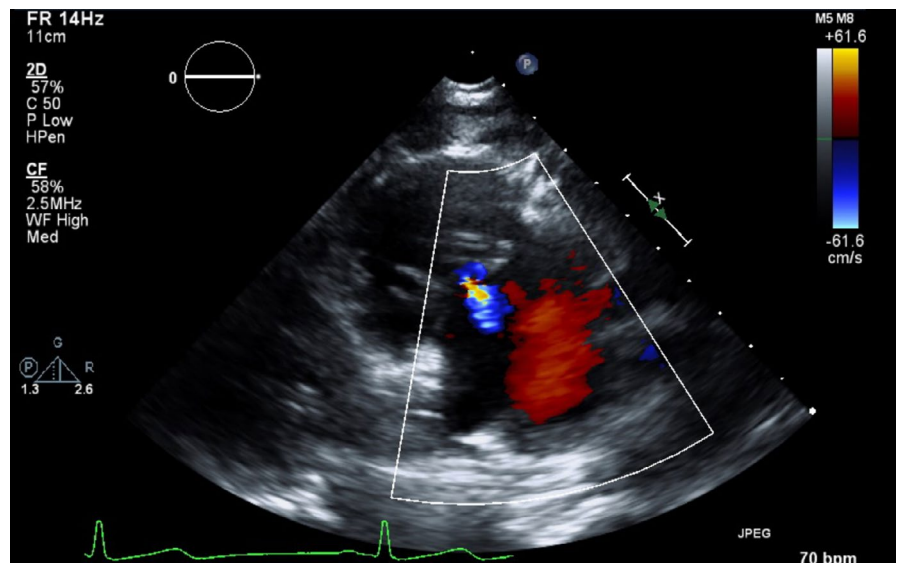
Parasternal long-axis image with posterior angulation 3 weeks after trauma showing tricuspid valve with mild regurgitation
